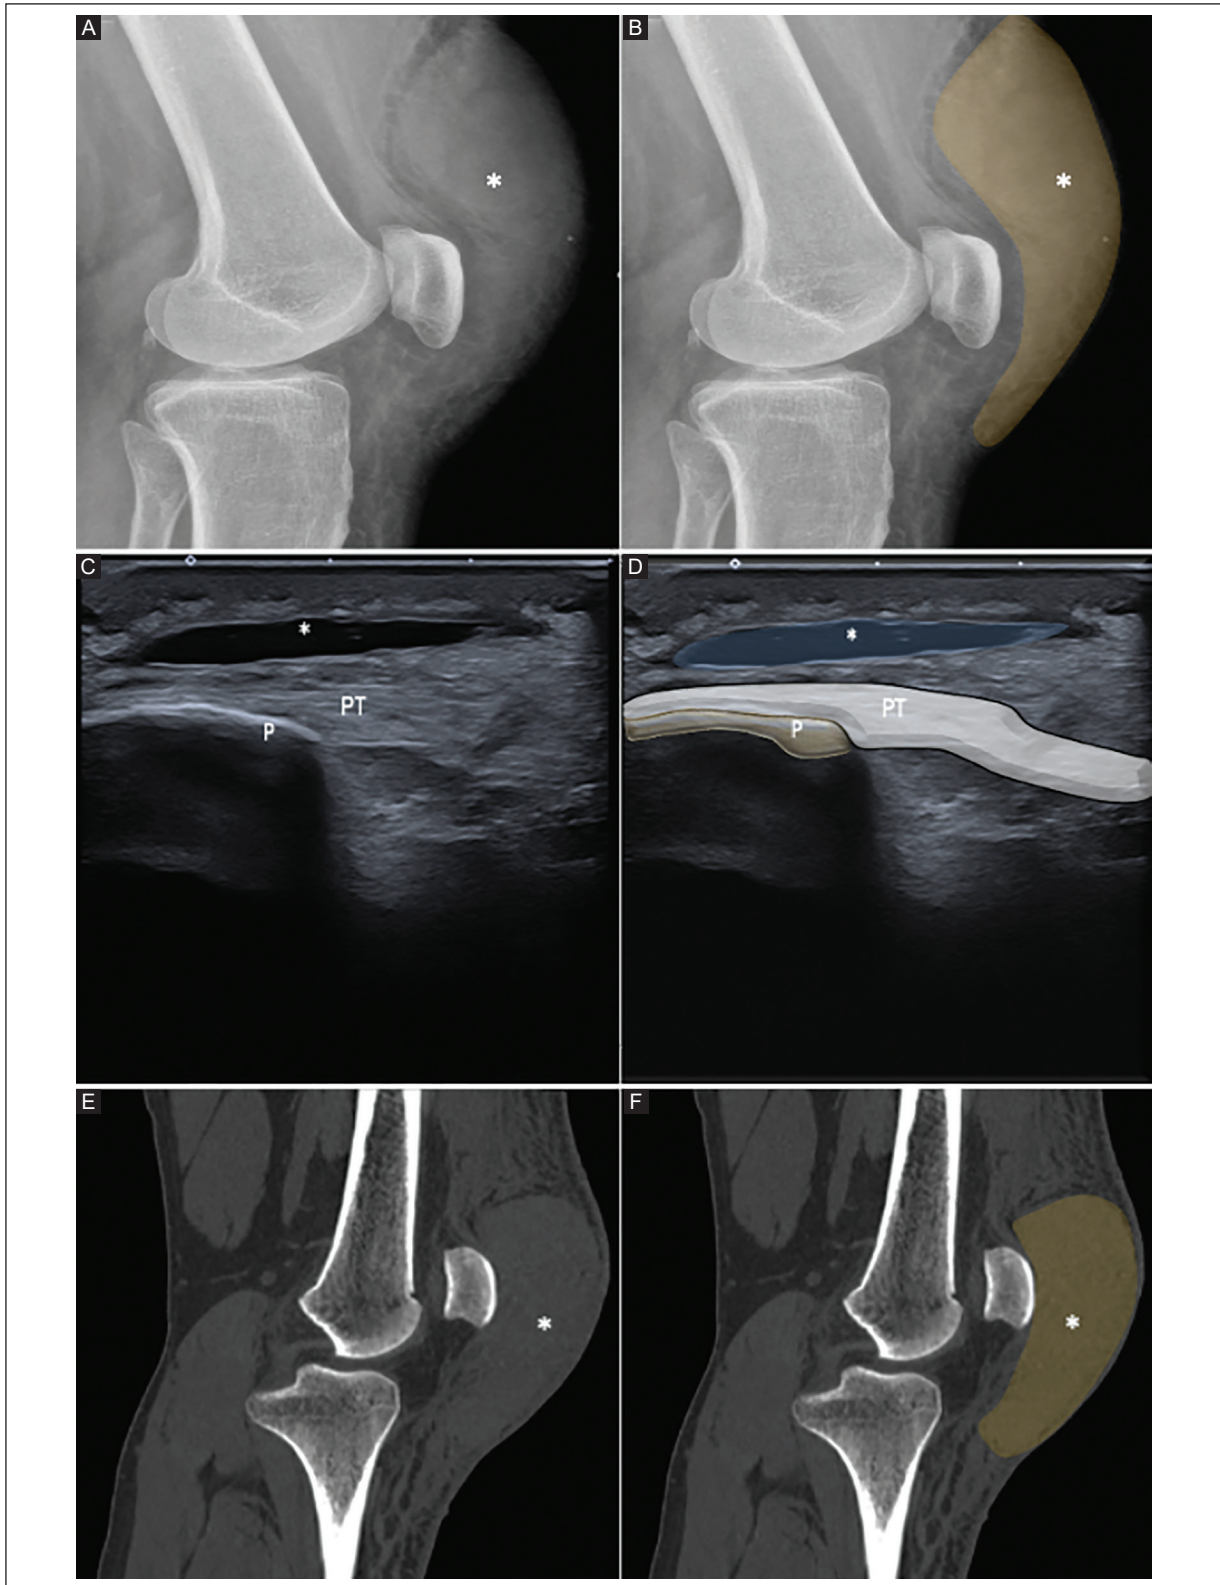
A-B: lateral knee X-rays in a 59-year-old woman show prominent soft-tissue swelling anterior to the patella (asterisks), highlighted in brown, consistent with prepatellar soft-tissue edema. C-D: sagittal US views show prepatellar bursitis, characterized by a well-defined anechoic collection of the prepatellar bursa (asterisks), superficial to the patella, with a thin wall and absence of vascularization, highlighted in blue, suggestive of aseptic (post-traumatic) bursitis. E-F: sagittal CT views show soft-tissue edema anterior to the patella (asterisks), highlighted in brown, with no associated bone abnormalities.
